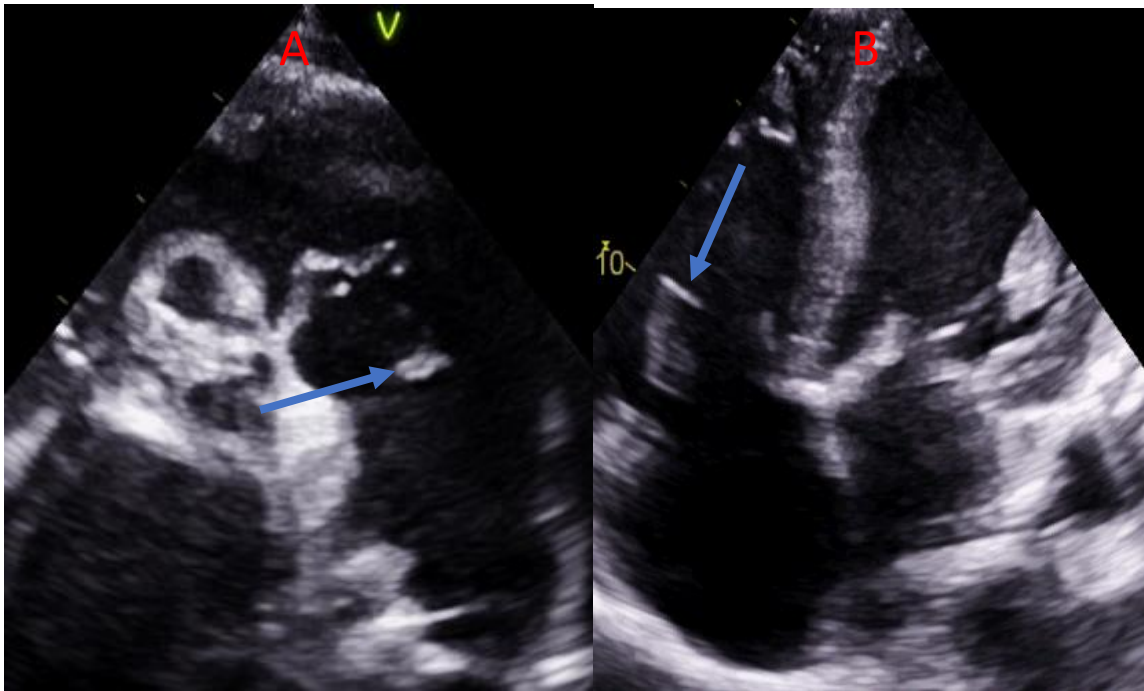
Transthoracic echocardiography: A- parasternal short axis view: dilacerated pulmonary valve seated with mobile echogenic formations, measuring 27mm long axis responsible for severe pulmonary leakage
